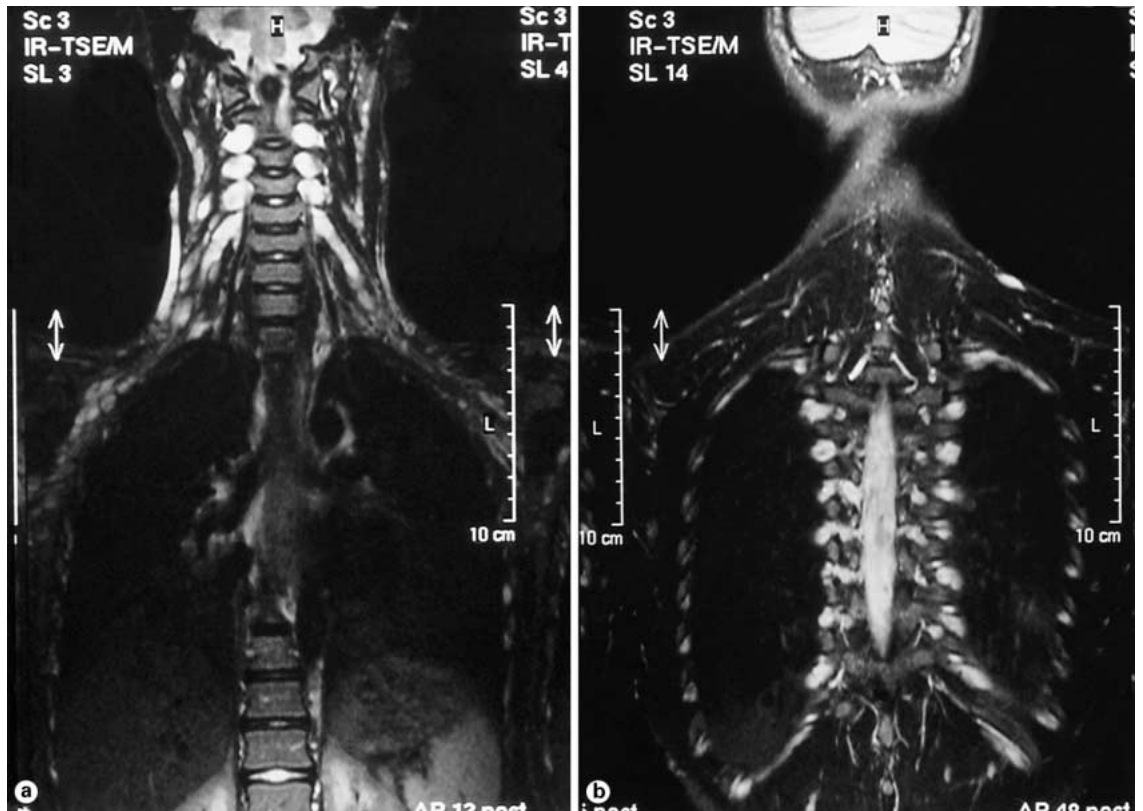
MR images of plexiform paravertebral neurofibroma-like neoplasms of the cervical (a) and thoracic (b) region.
